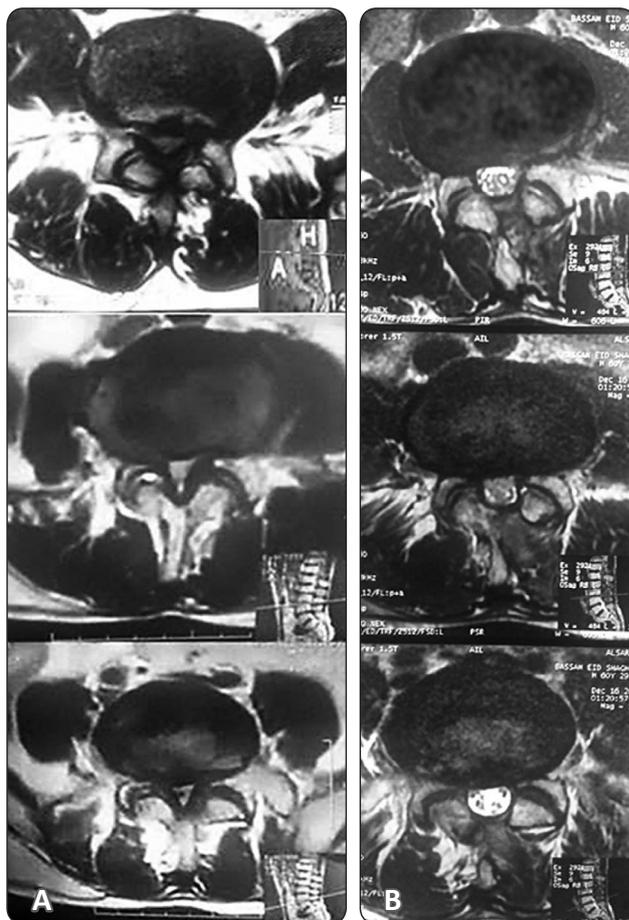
(A) Preoperative Axial T2-weighted MRI in a patient with L2,3,4 LCS (B) Postoperative axial T2-weighted MRI of same patient.
